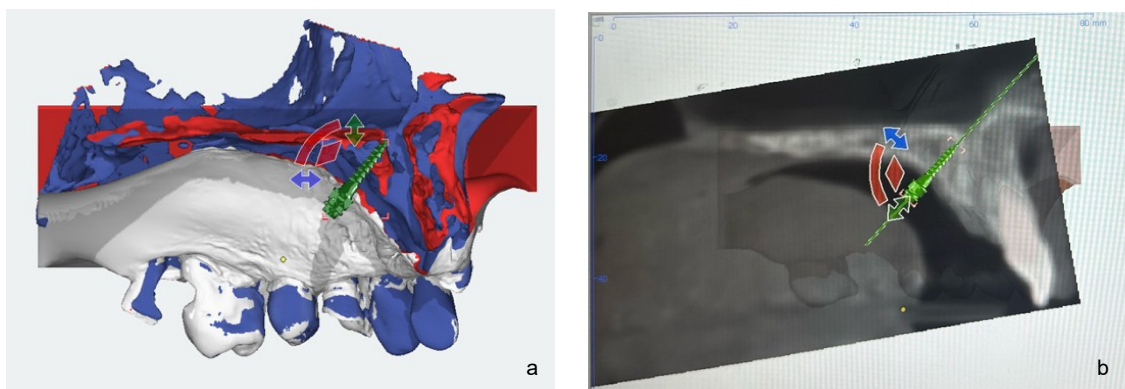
Virtual implant placement a. OMI placement using the 3D cursor for all planes b. OMI placement with superimposition of the CBCT dataset
